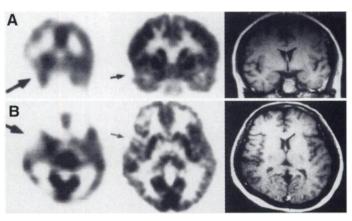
Coronal sections (A) and transaxial sections (B) of 37-yr-old female patient (Patient 3). Brain ^{99m}Tc-HMPAO SPECT (left) and brain FDG PET (middle) reveal area of both hypoperfusion and hypometabolism in right temporal lobe (arrow). However, brain MR image (right) shows no significant abnormality.
